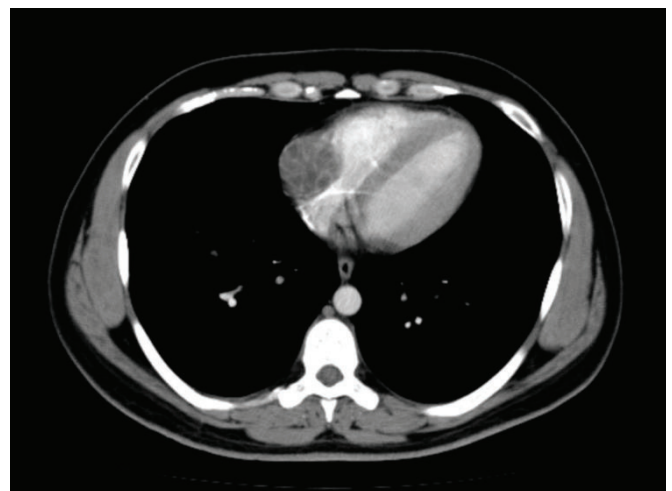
Computed tomography image of a cardiac hydatid cyst.
